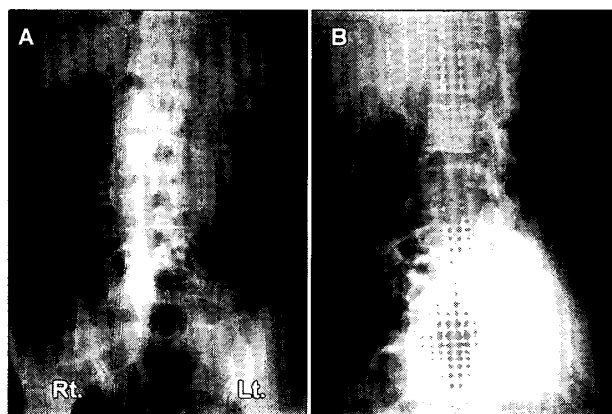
Plain roentgenograms showing L4 degenerative spondylolisthesis, without scalloping of the vertebra.
